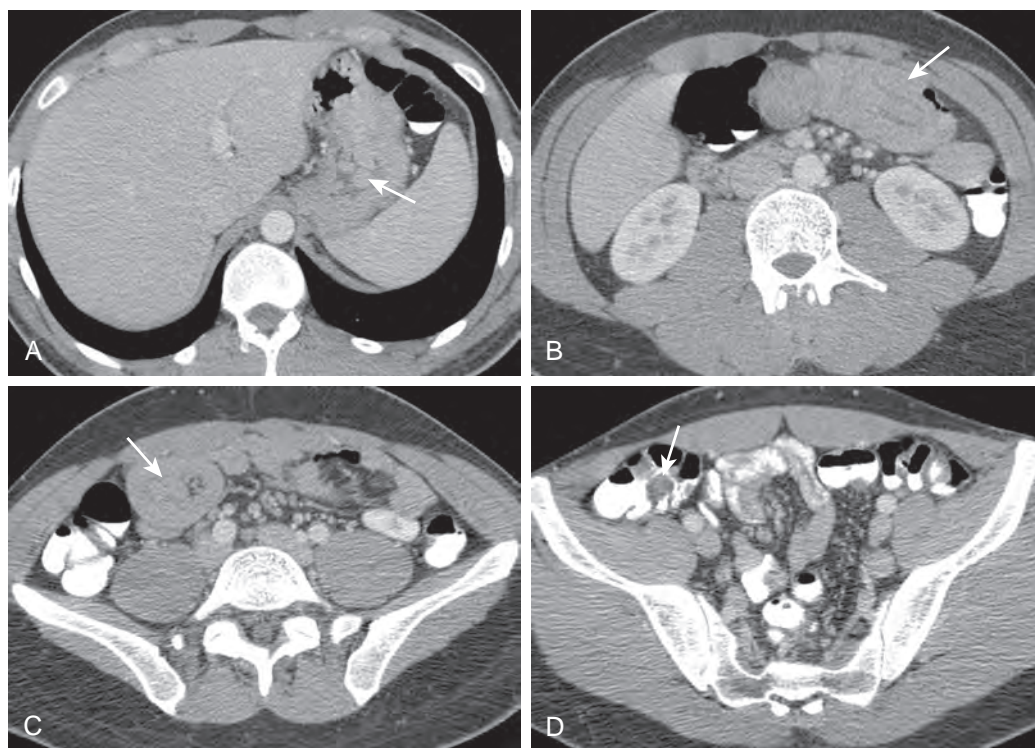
Peutz-Jeghers syndrome in a 22-year-old man who presented with acute abdominal pain, nausea, and vomiting. A-D. Intravenous and oral contrast-enhanced CT shows multiple hamartomas polyps throughout the gastrointestinal tract. Polyps are present in the stomach and colon (arrows in A and D). Two small bowel intussusceptions are present (arrows in B and C).
